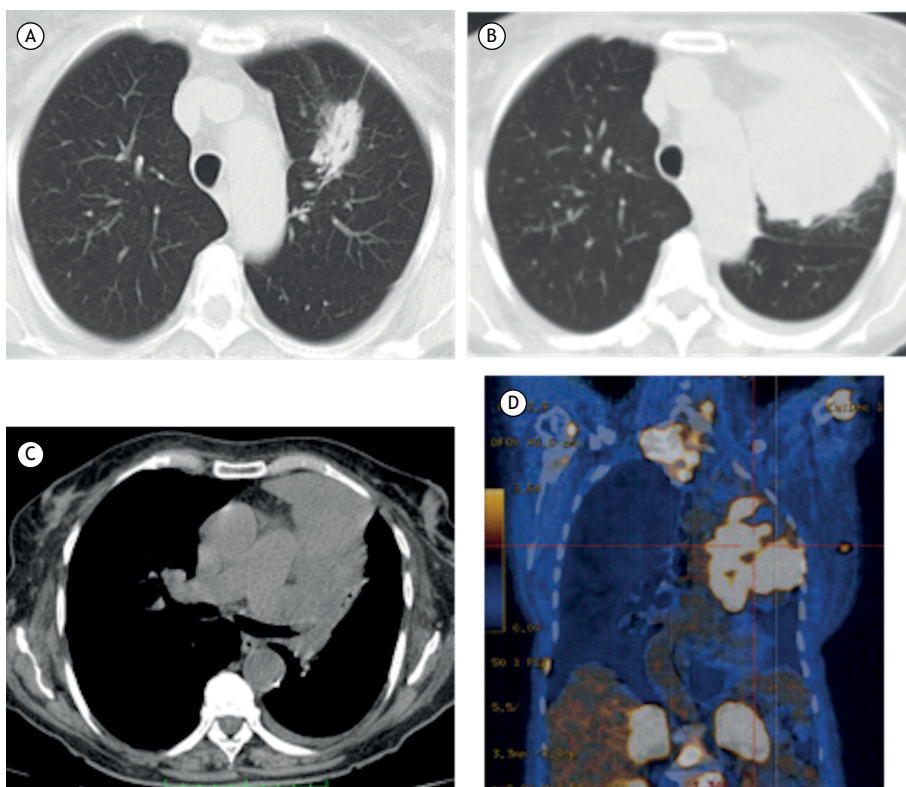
Evolution of angiosarcoma in a 78-year-old female nonsmoker: in A, initial CT scan of the chest showing a left upper lobe pulmonary mass; in B and C, CT scans of the chest, obtained two years later, showing a 10 × 7 cm lesion in the left upper lobe, with a small left pleural effusion and small mediastinal lymph nodes; in D, an ^{18}F -fluorodeoxyglucose positron emission tomography-CT scan showing increased metabolic activity in many organs, greatest in the mass in the upper left lobe.
